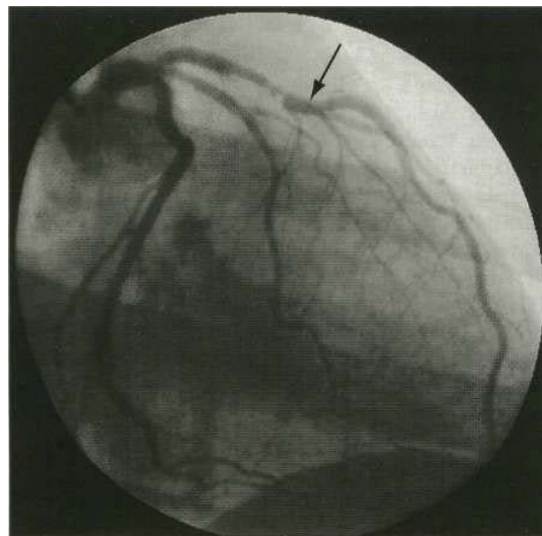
Left coronary angiogram. X-ray contrast material is injected into the ostium of the left main coronary artery. In this example, the left main artery divides into three vessels: left anterior descending (top), diagonal and circumflex (bottom) vessels. In the proximal part of the left anterior descending artery is a severe narrowing due to an atherosclerotic plaque (arrow).
